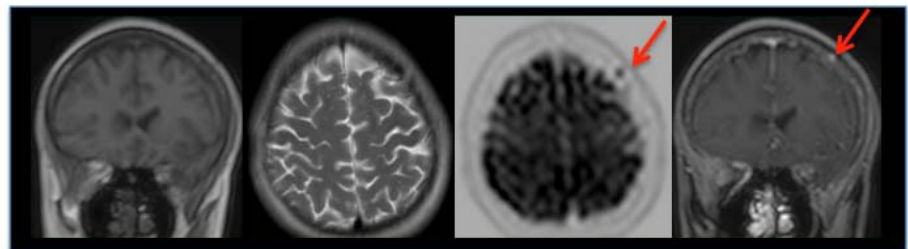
Example of focal multiple myeloma skull involvement. From left to right: Pre-contrast in phase mDixon, T2-TSE, inverted b1000 DWI and post-contrast water only mDixon showing a focal lesion in skull not visible on anatomical MRI, but apparent on additional MR sequences (DWI + Post-contrast) (red arrows).
